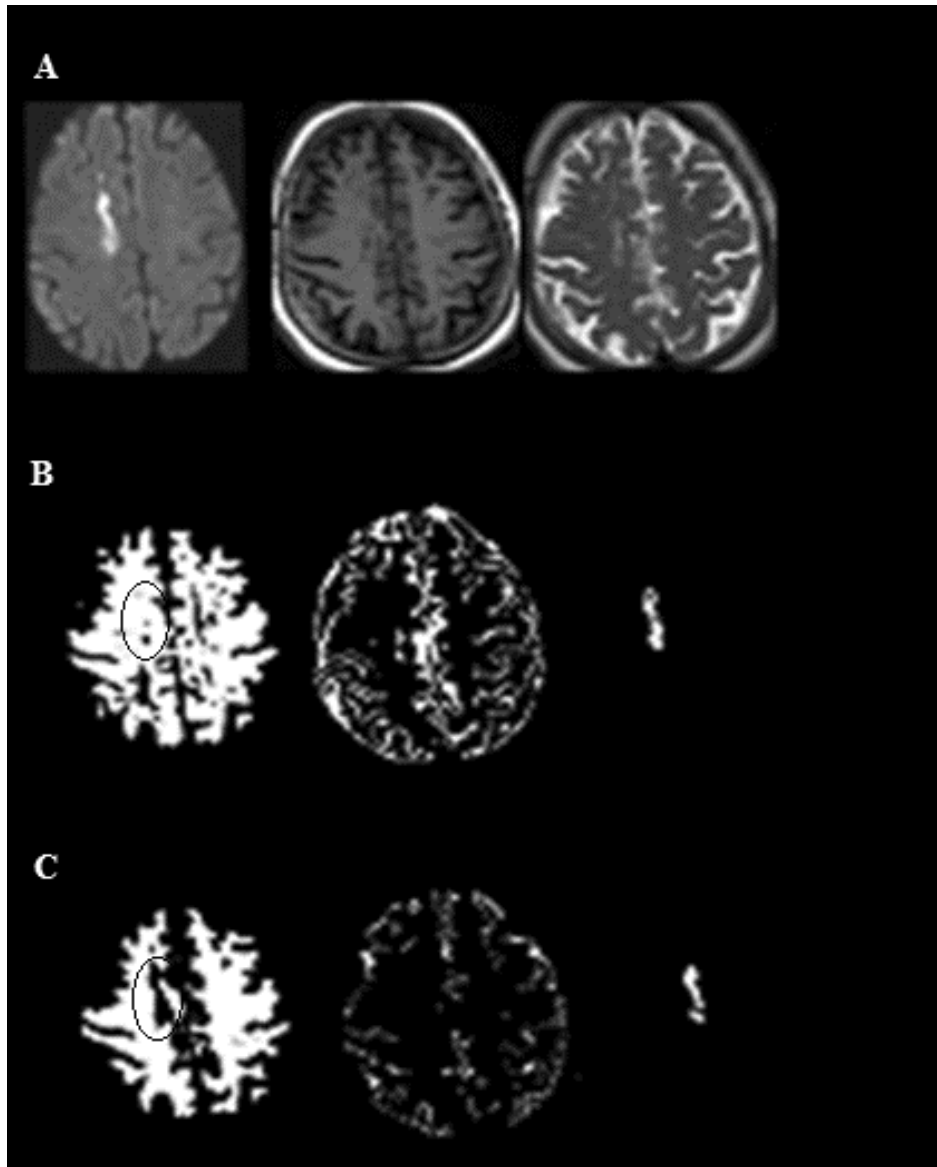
Classification Results using Dataset 2: (from left to right) A) Input Slices DWI, T1WI and T2WI; B) ICA Results, WM, GM and Abnormal Tissue; C) MICA Results WM, GM and Abnormal Tissue
